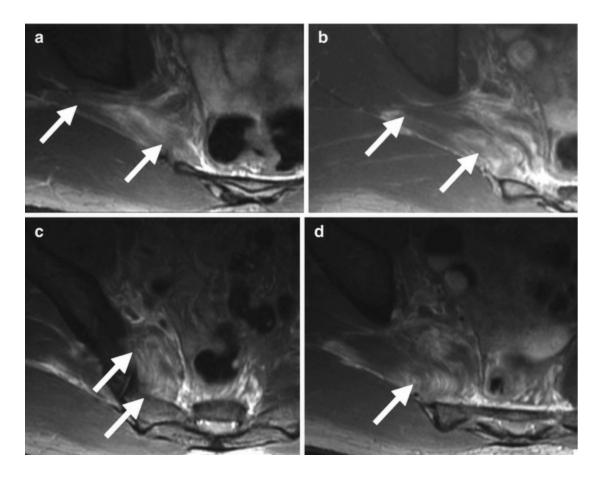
A 25-year-old professional rugby player with a traumatic piriformis muscle injury. Axial T2-weighted fat-suppressed MRI at different levels (a–d) of the piriformis muscle (*arrows*) showing an area of hyperintense focus in the piriformis muscle belly with partial disorganization of the muscle fibers (Reproduced with the permission of Drs Alain Silvestre and Philippe Meyer, Center of Osteoarticular Imaging, Sports Clinic, Mérignac, France)
